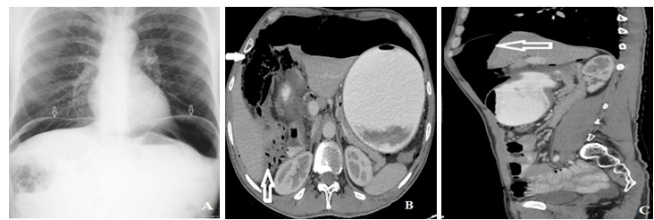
Direct abdominal radiography (A), axial abdominal tomography image (B), sagittal abdominal tomography image (C) 50 years male patient. Arrows show free air in abdominal area and retroperitoneum.
